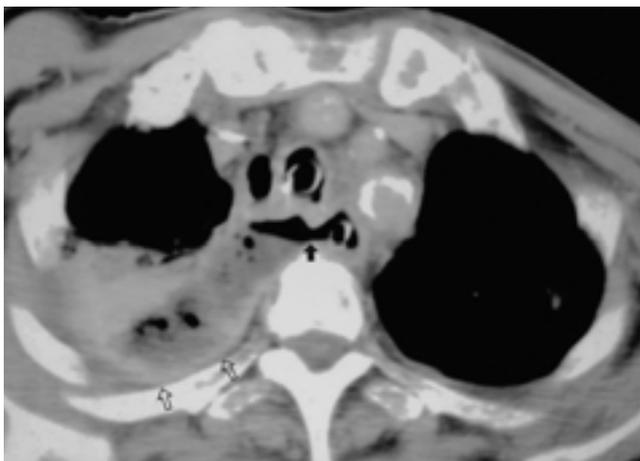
Idiopathic esophageal perforation in a 69-year-old man. Enhanced CT scan at thoracic inlet level shows discontinuity in esophageal wall and extraluminal air (arrow) extending from esophageal lumen. Associated pulmonary consolidation and pleural empyema (open arrows) are also noted. We predicted that perforation site was upper esophagus. Upper esophageal perforation was confirmed by esophagography (not shown).
